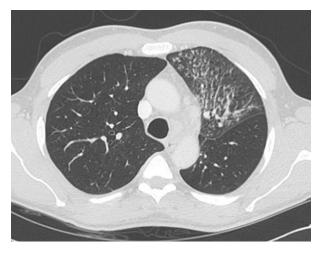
Chest CT scan showing postobstructive volume loss with patchy centrilobular micronodular opacities in the left upper lobe.
